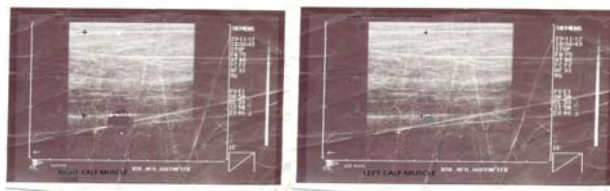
Sonographs for the Right and Left CMT.
